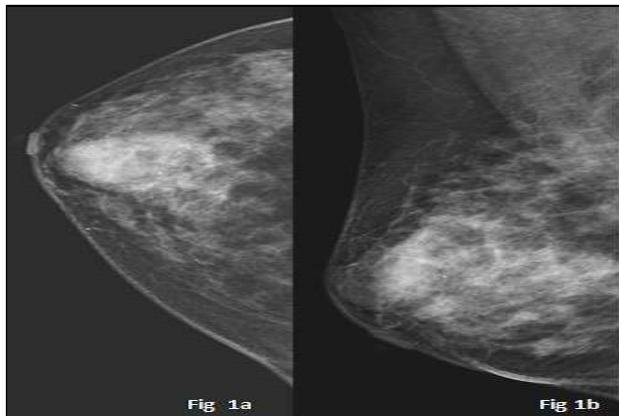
X-ray mammogram showing oval hyperdense lesion with partially obscured borders superolateral to nipple in CC (Figure a) and RMLO (Figure b) views.
